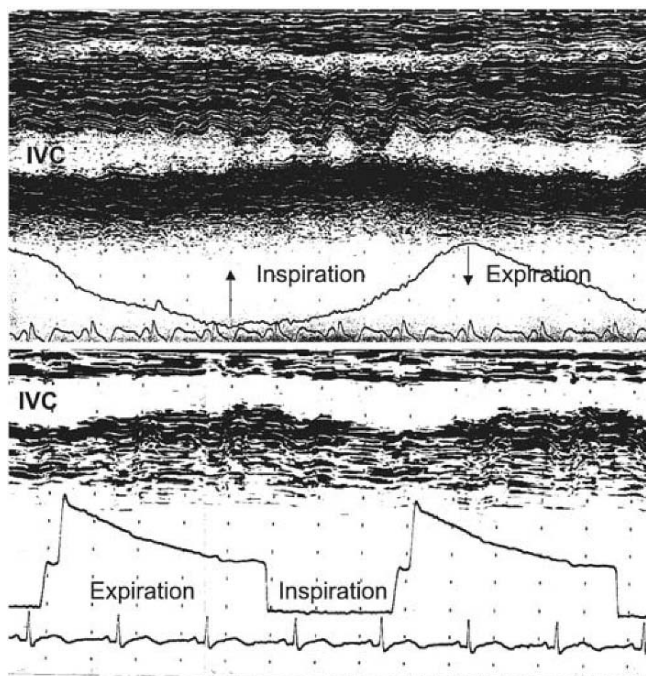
M mode echocardiography of the inferior vena cava (IVC) in a spontaneously breathing healthy volunteer (*above*) and in a mechanically ventilated patient (*below*). Cyclic changes in IVC diameters are opposite, the largest value being observed during expiration in spontaneous breathing, and during inspiration in positive pressure breathing
